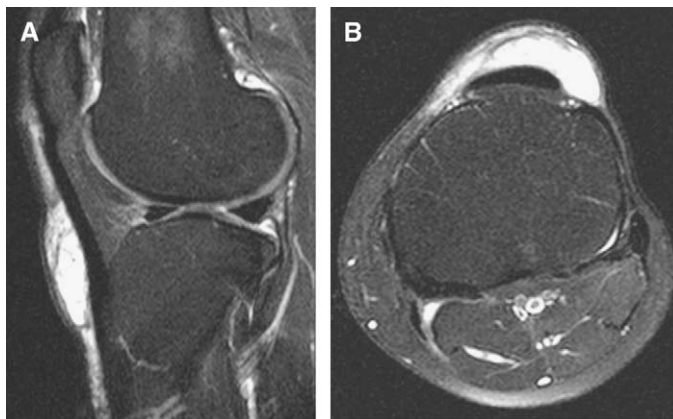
{A,B} Prepatellar bursitis. T2-weighted images demonstrates fluid signal intensity superficial to the patellar tendon, consistent with prepatellar bursitis.
